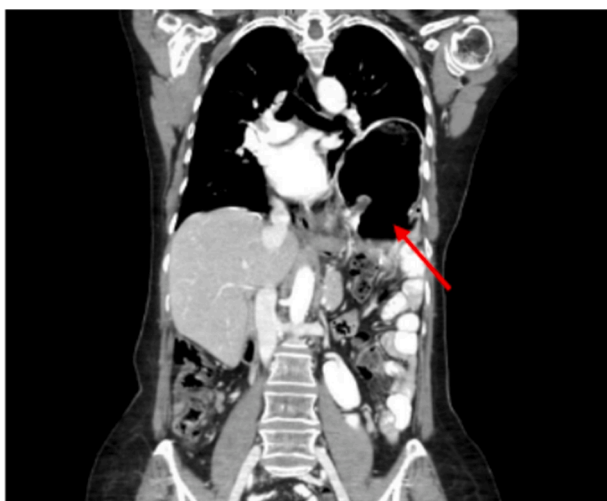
Computed Tomography (CT) scan: large left diaphragmatic hernia with stomach and bowel content (arrow).
